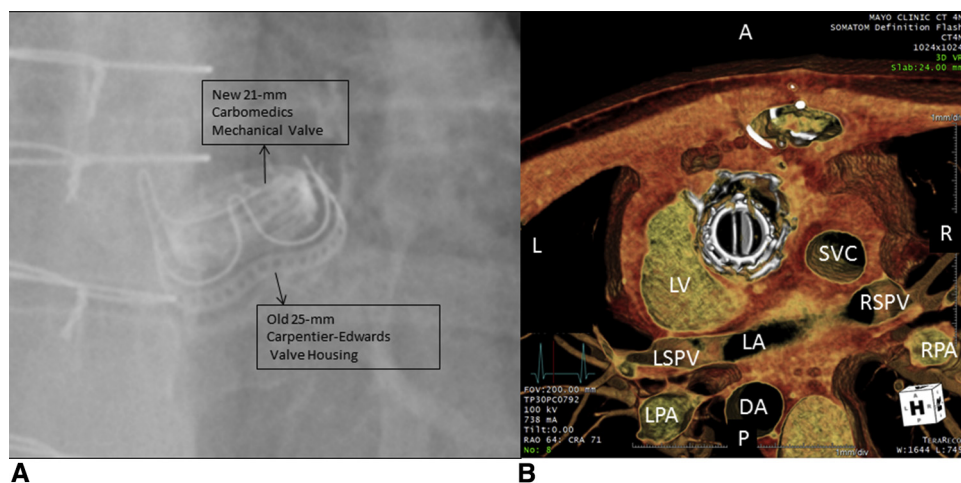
A, Chest roentgenogram. B, Functional aortic valve leaflets on cardiac computed tomographic angiography. A, Anterior; L, left; R, right; LV, left ventricle; SVC, superior vena cava; RSPV, right superior pulmonary vein; LSPV, left superior pulmonary vein; LA, left atrium; RPA, right pulmonary artery; LPA, left pulmonary artery; DA, descending aorta; P, posterior.
